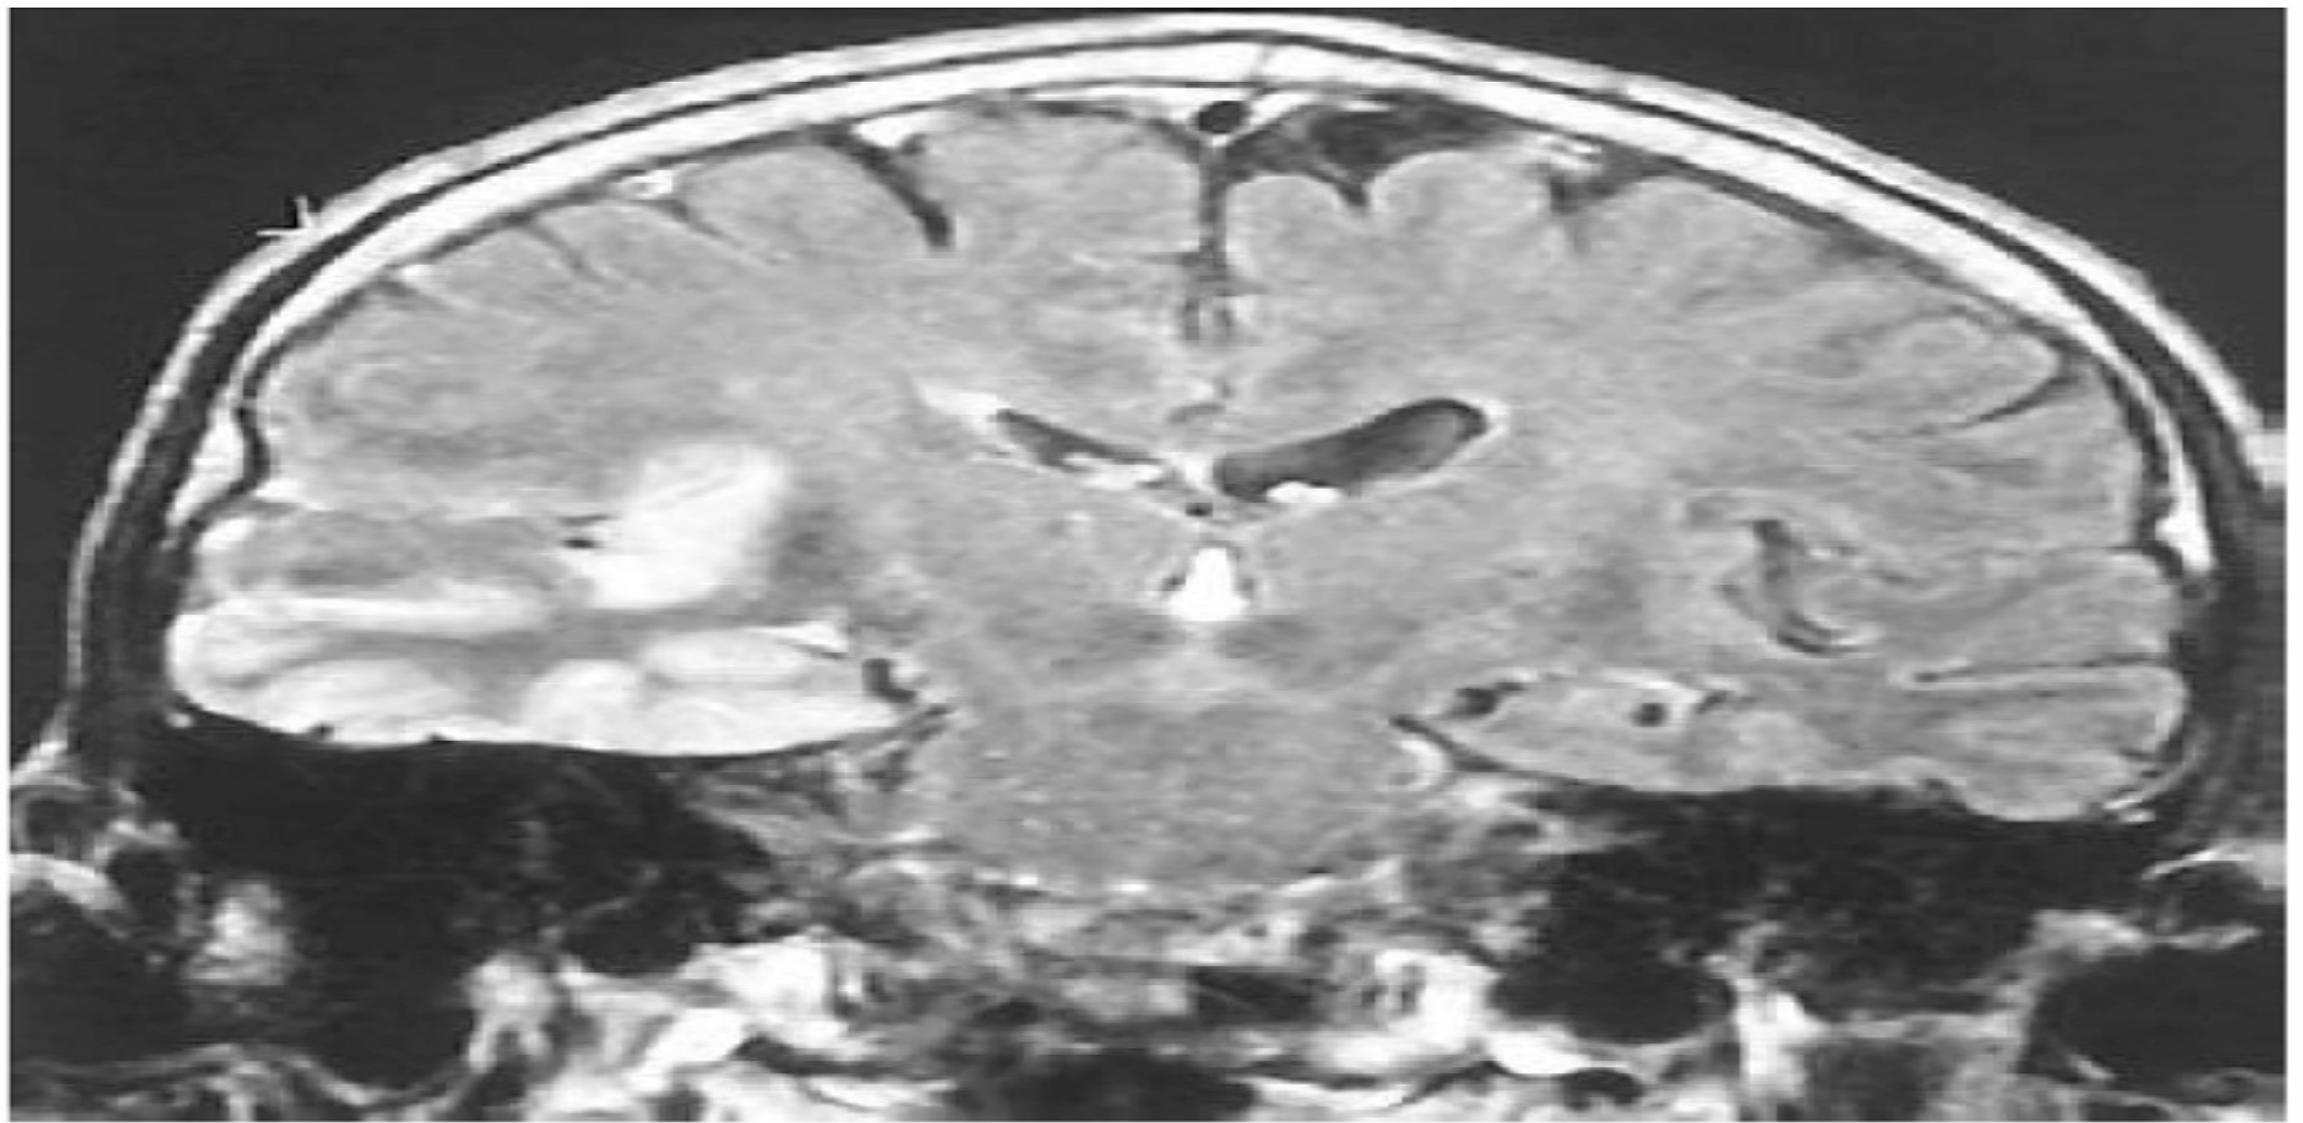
Coronal fluid-attenuated inversion recovery (FLAIR) magnetic resonance image from a patient with herpes simplex encephalitis. Note the area of increased signal in the right temporal lobe (*left side of image*) confined predominantly to the gray matter. This patient had predominantly unilateral disease; bilateral lesions are more common but may be quite asymmetric in their intensity.
